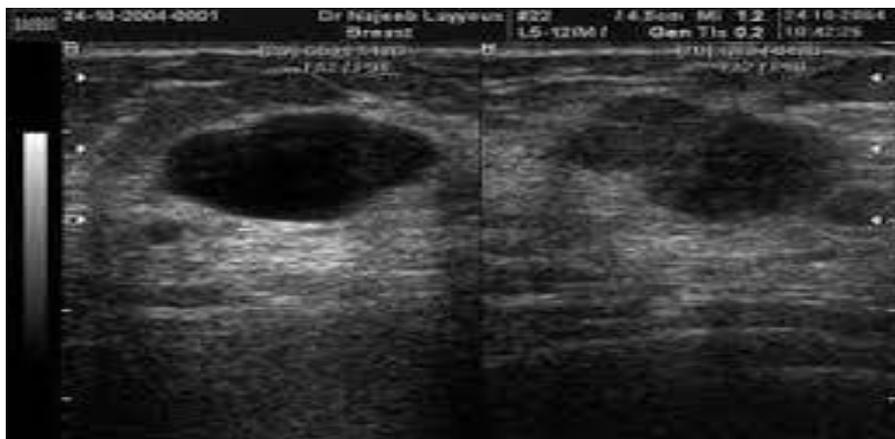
Ultrasound of breast shows fibroadenoma.
